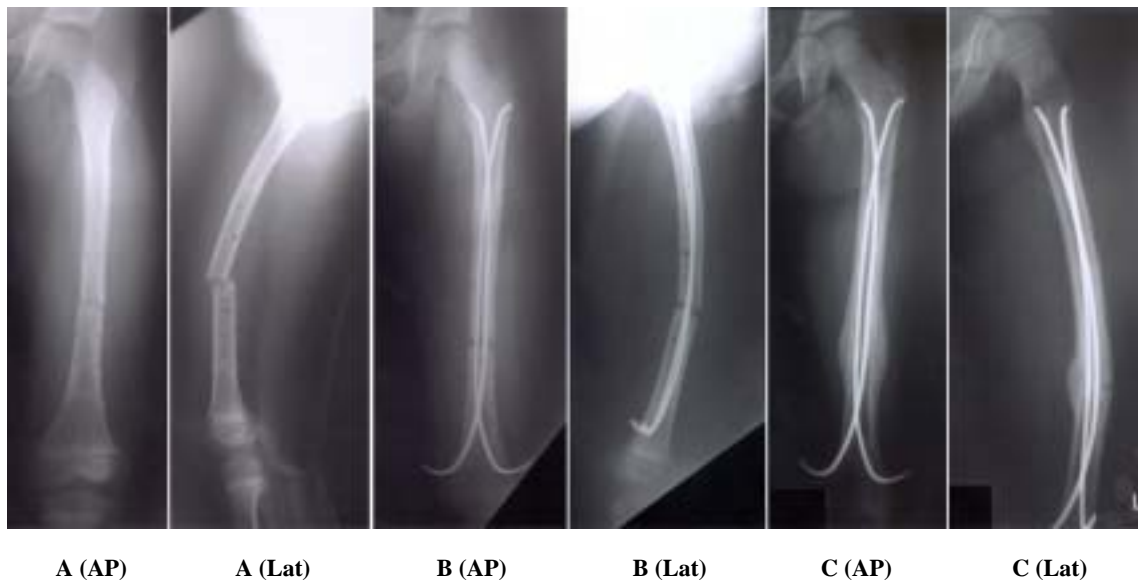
Serial radiograph of 7 year old boy treated by Nancy nail.
